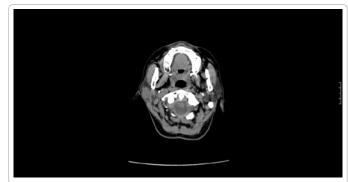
Maxillofacial MRI showing space occupying lesion within the superficial lobe of the parotid gland.
